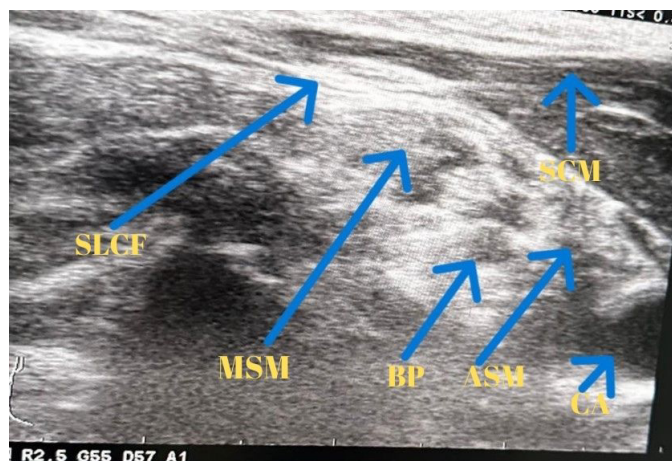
Ultrasonographic view of superficial cervical plexus
